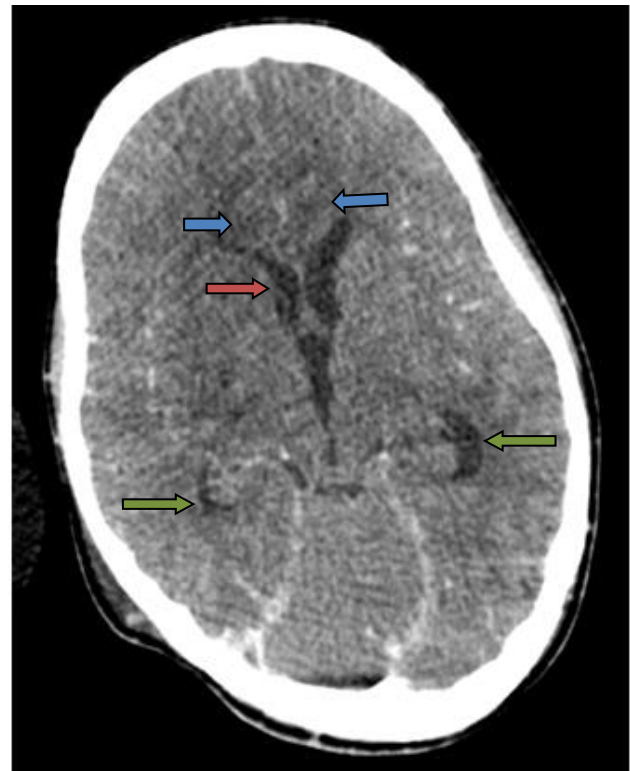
Post contrast CT brain showing acute infarcts in both frontal lobes in parafalcine location (blue arrows) and in the right caudate (red arrow). There is prominence of the temporal horns of the lateral ventricles consistent with early hydrocephalus (green arrows).
